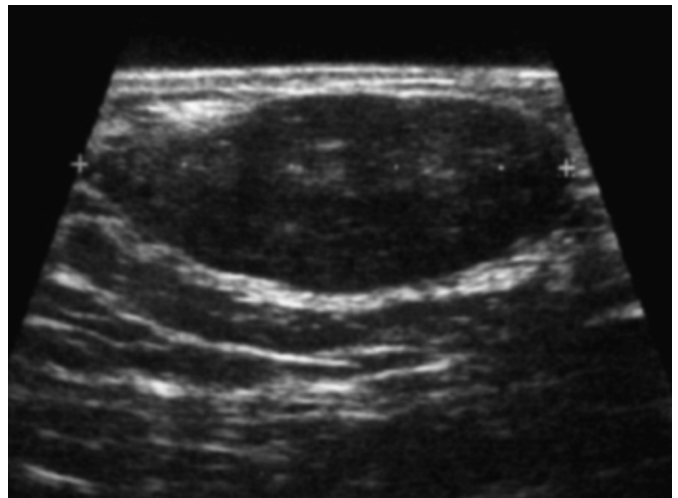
Sonography: inhomogeneous hypoechoic oval mass with well defined margins.
